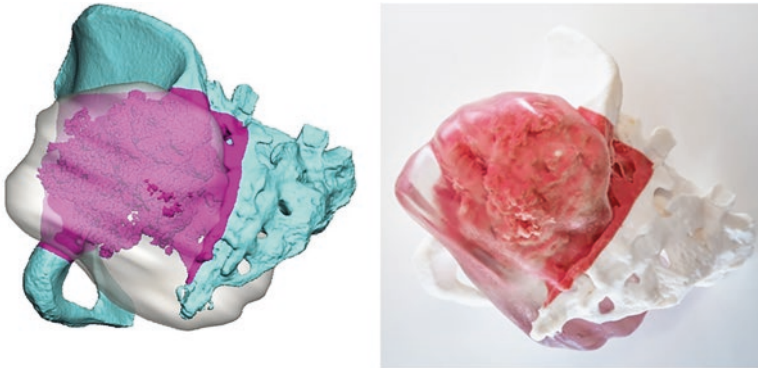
Left pelvis chondrosarcoma model with resection plan—bony pelvis model derived from the CT and soft tissue tumor model from the MR image data
